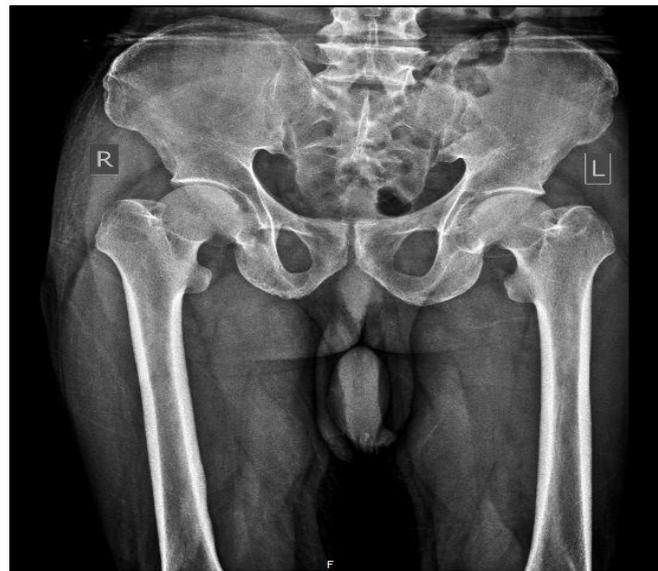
AP Pelvic Radiograph in a 44-Year-Old Male with HCH.
